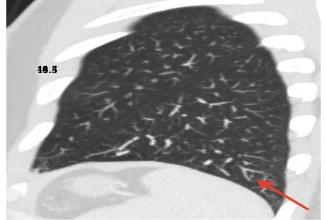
Contrast enhanced CT (sagittal view) showing a small nodule along the peribronchovascular bundle (red arrow).
